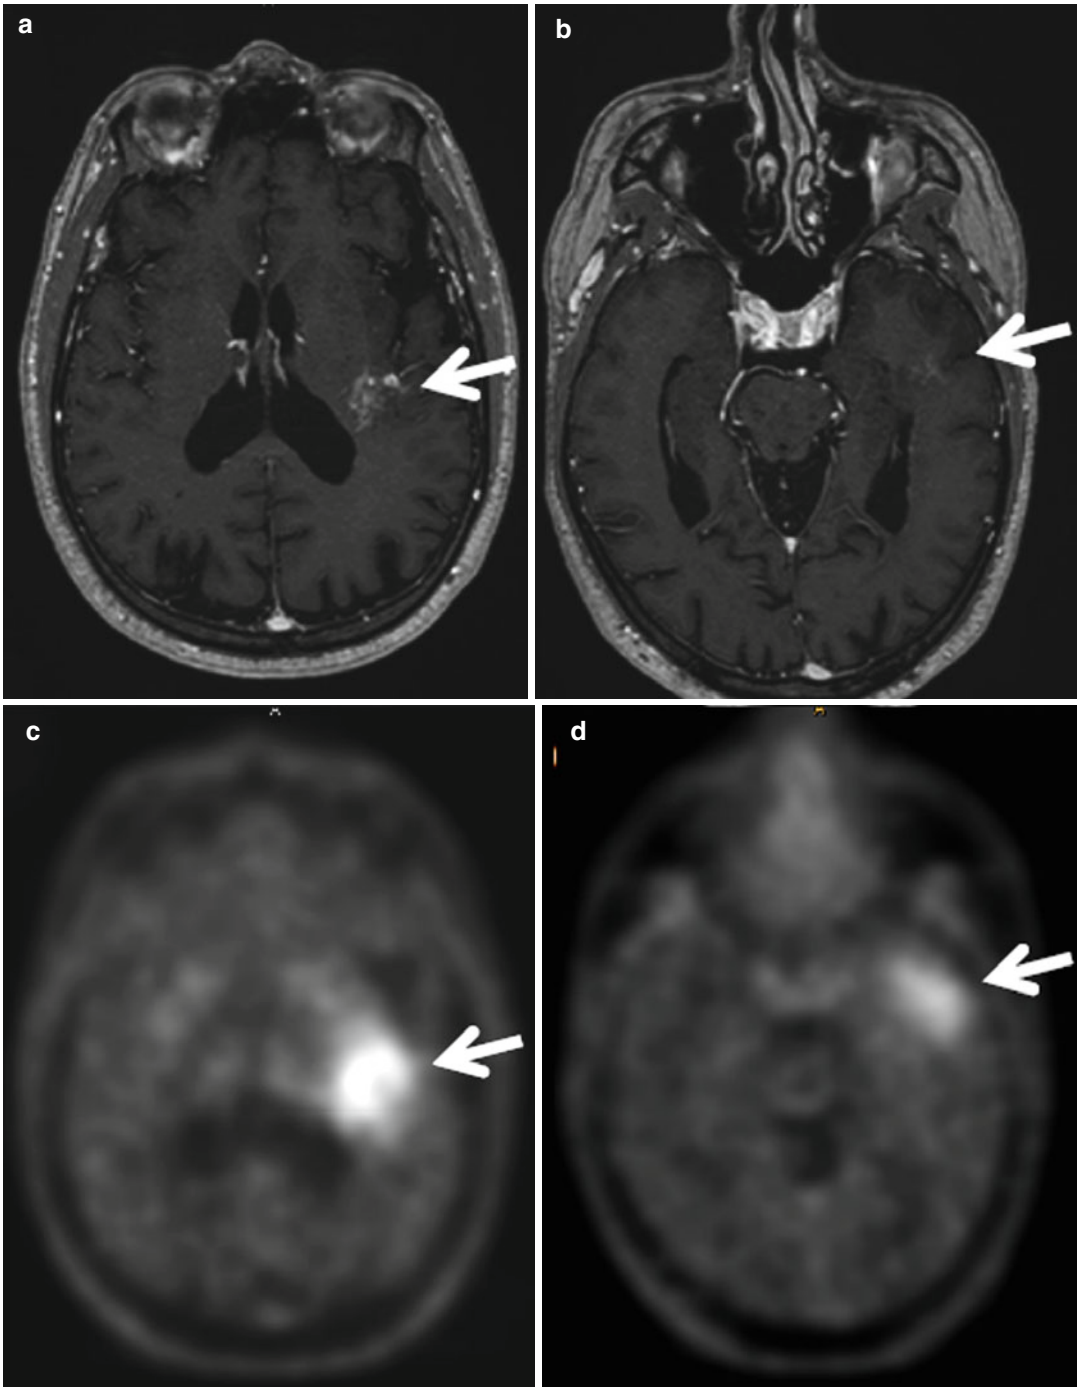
Imaging for radiotherapy planning of a patient with recurrent glioblastoma. (a, b) Two axial slices of the MRI scan (contrast-enhanced T1 sequence) with areas of pathological contrast enhancement (*white arrows*). (c, d)
